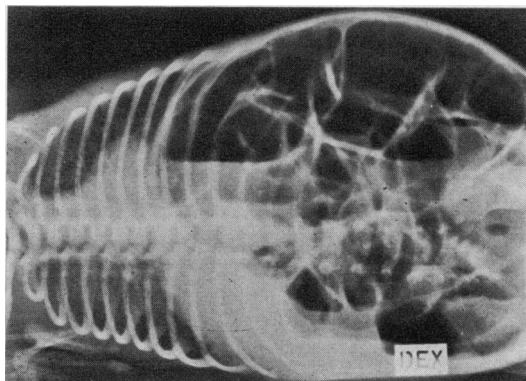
X-ray of the distended abdomen of a newborn CCD patient. Intestinal loops are dilated with fluid and air and a hydroperitoneum is present.
